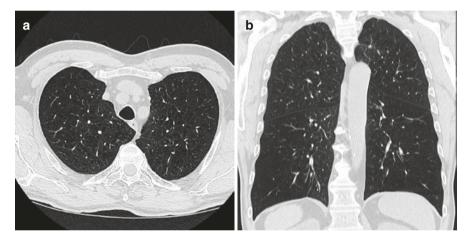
(a) HRCT of the lungs: centrilobular emphysema. (b) HRCT of the lungs (coronal reconstruction): centrilobular emphysema
